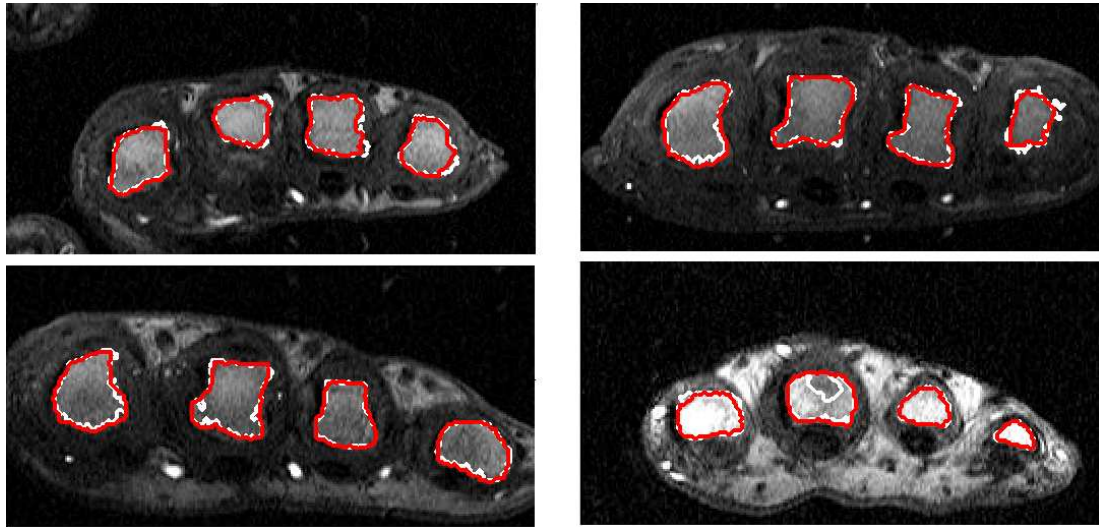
The bone interiors segmented with the preliminary segmentation (in white), and the adaptive segmentation (in red) in images drawn from four DCE-MRI studies acquired with the high-field scanner.
